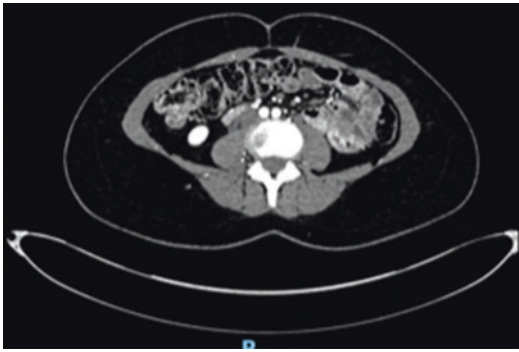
Axial CT scan revealing a left paraumbilical perforator suitable for a DIEP flap
